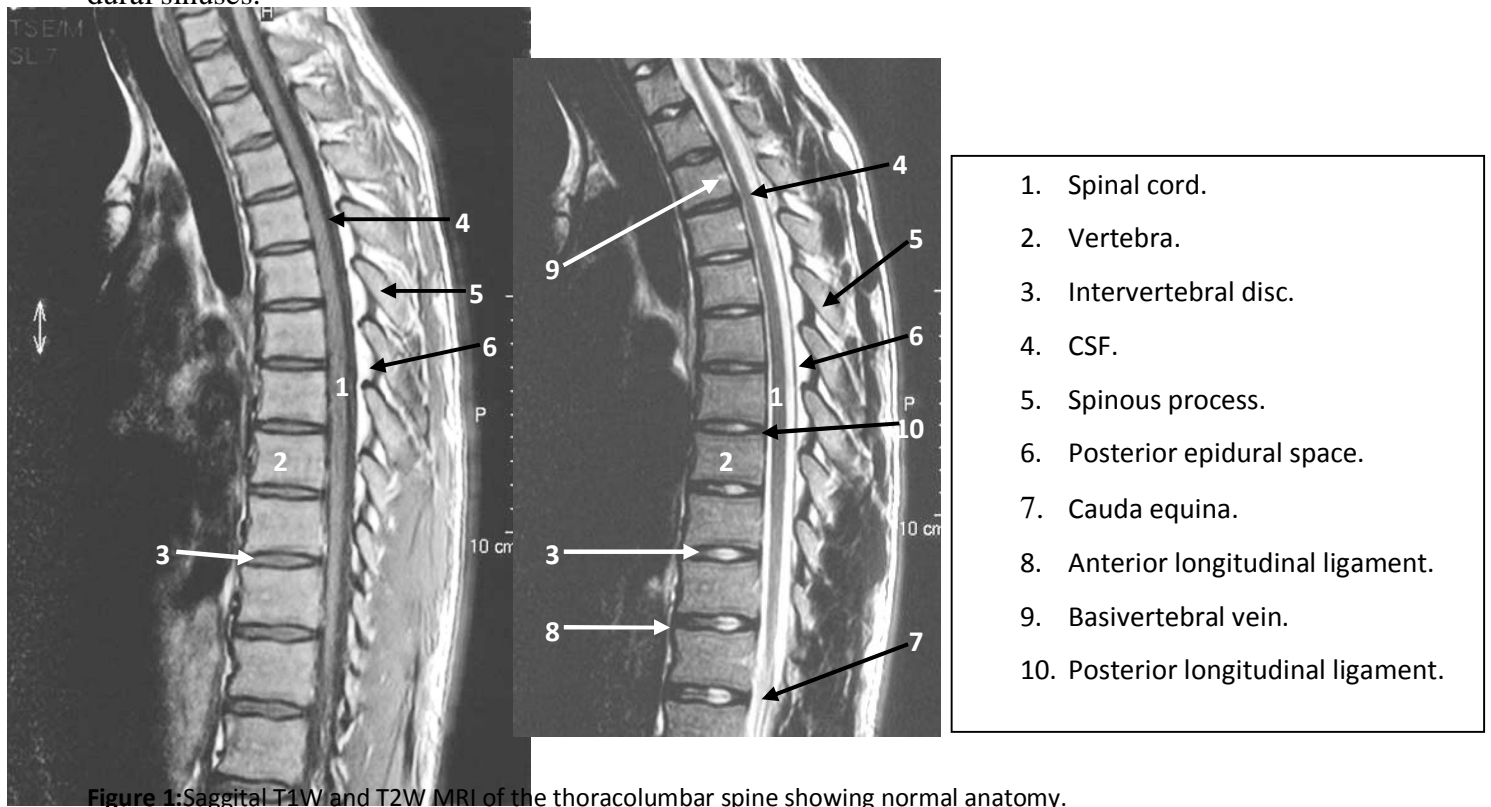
Saggital T1W and T2W MRI of the thoracolumbar spine showing normal anatomy.
